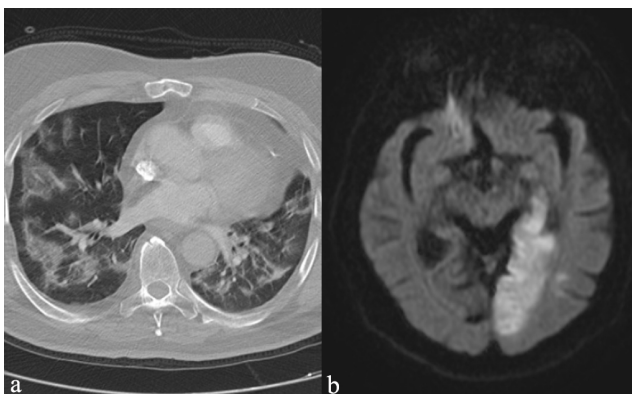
MR images of diffuse COVID-19 pneumonia in both lungs (a) and diffusion restriction showing left temporooccipital acute ischemic stroke in the same patient
